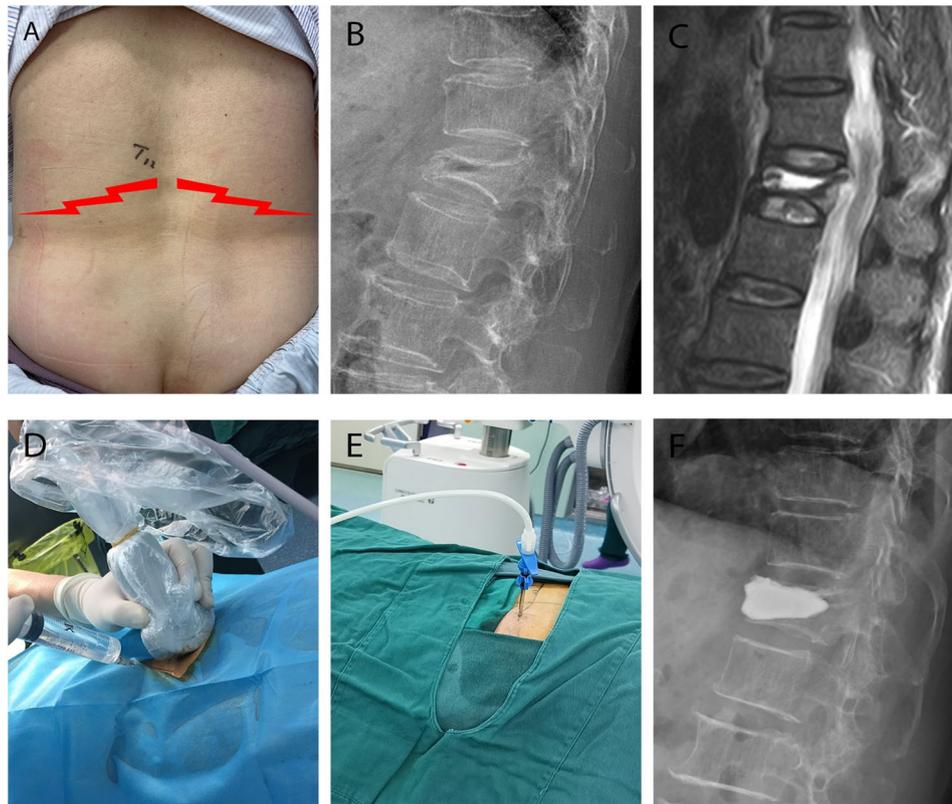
An 82-year-old woman with an osteoporotic compression fracture at T12 and intercostal neuralgia undergoing percutaneous kyphoplasty under thoracic paravertebral block. A: Lightning symbol indicates location of intercostal neuralgia. B: Preoperative lateral X-ray shows T12 compression fracture. C: Preoperative T2-weighted MRI reveals T12 compression with canal occupation. D: Ultrasound-guided thoracic paravertebral block. E: Intraoperative view of percutaneous kyphoplasty. F: Postoperative lateral X-ray shows well-dispersed cement and restored vertebral height
